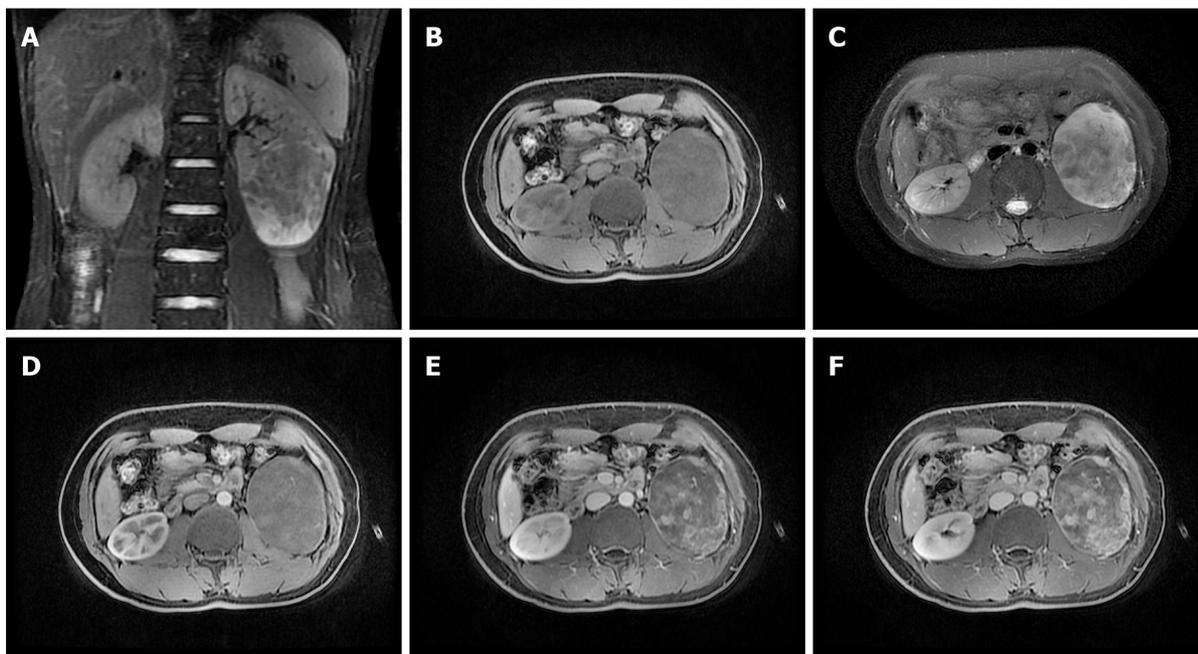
Moderate or mild enhancement in the solid component after contrast enhancement. A: Coronal T2-weighted image showing an exophytic cystic-solid mass in the lower pole of the left kidney; B: Cystic region shows T1 hypointensity and T2 hyperintensity; C: Solid region shows T1 hypointensity and T2 hyperintensity; D: Contrast-enhanced magnetic resonance imaging during the corticomedullary phase; E: Nephrographic phase; F: Excretory phase showing that the tumor's cystic parts were not enhanced and the tumor's solid parts were enhanced to a moderate or mild degree that increased with time.
